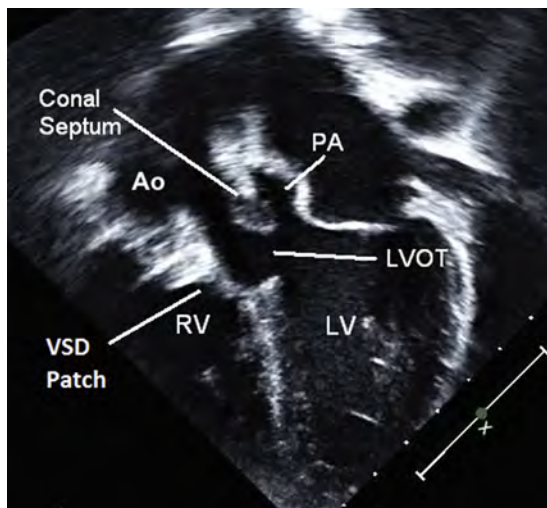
Apical five-chamber view of a patient after the Rastelli procedure demonstrates the pathway from the left ventricle (LV) to the aorta (Ao) after baffling with a VSD patch. Note the conal septum, which is deviated posteriorly and the hypoplastic pulmonary artery (PA) stump (the PA is tied off during the procedure). LVOT, LV outflow tract; RV, right ventricle.
